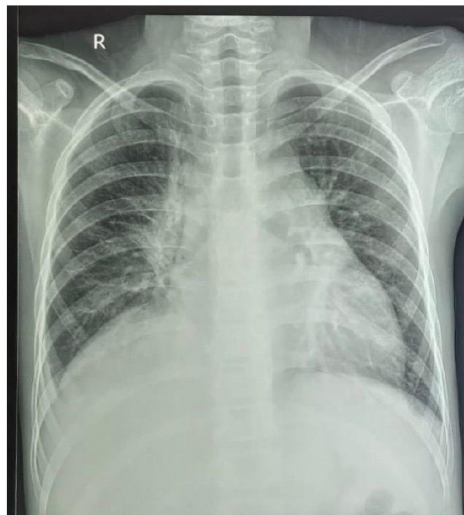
Chest X-ray of Case 2
